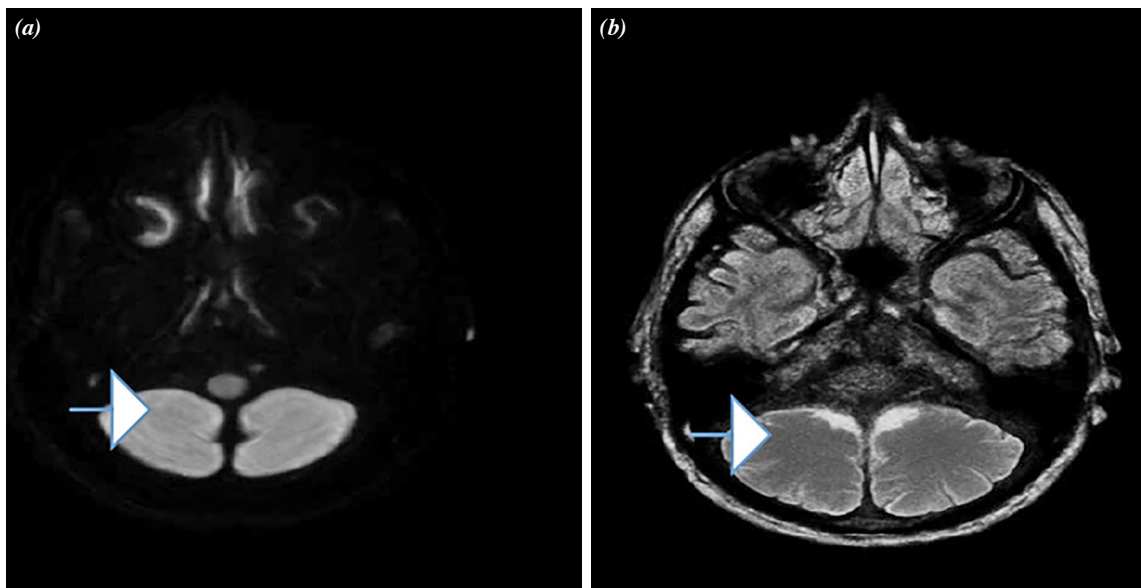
(a) Diffusion-weighted cranial magnetic resonance imaging with tetra brightness in the cerebellar parenchyma, and (b) its equivalent axial T2-weighted images.
